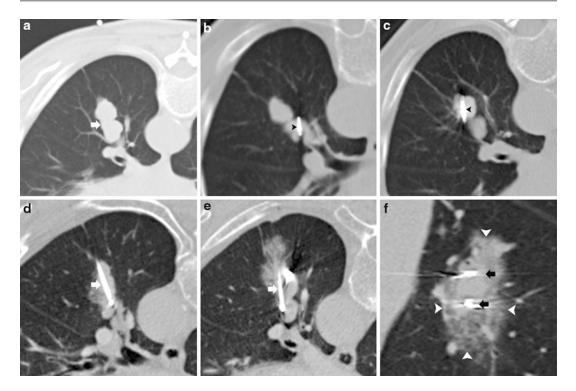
Combined radiotherapy and RF ablation for right lower lobe colorectal metastases: (a) Prone axial CT image demonstrates two right lower lobe nodules (*white arrow*). (b) Interval placement of a fiducial marker in the superior and medial pulmonary nodule (*arrowhead*) for stereotacic radiotherapy. (c) Interval placement of a fiducial marker in the inferior and lateral pulmonary nodule (*arrowhead*) for stereotactic radiotherapy. (d) Post-radiotherapy CT image shows interval placement
